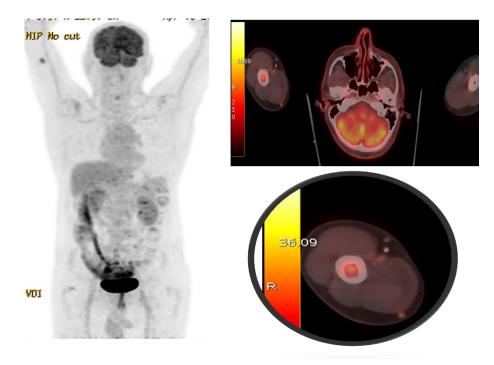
Whole body 18FDG PETCT showing right thalamic lesion noted in MRI showed FDG uptake greater than white matter and lesser than grey matter and metabolically active soft tissue density lesion in mid shaft of right humerus suggestive of bone deposit (1.5x1.3x1.1cm with SUV max of 5.3).
